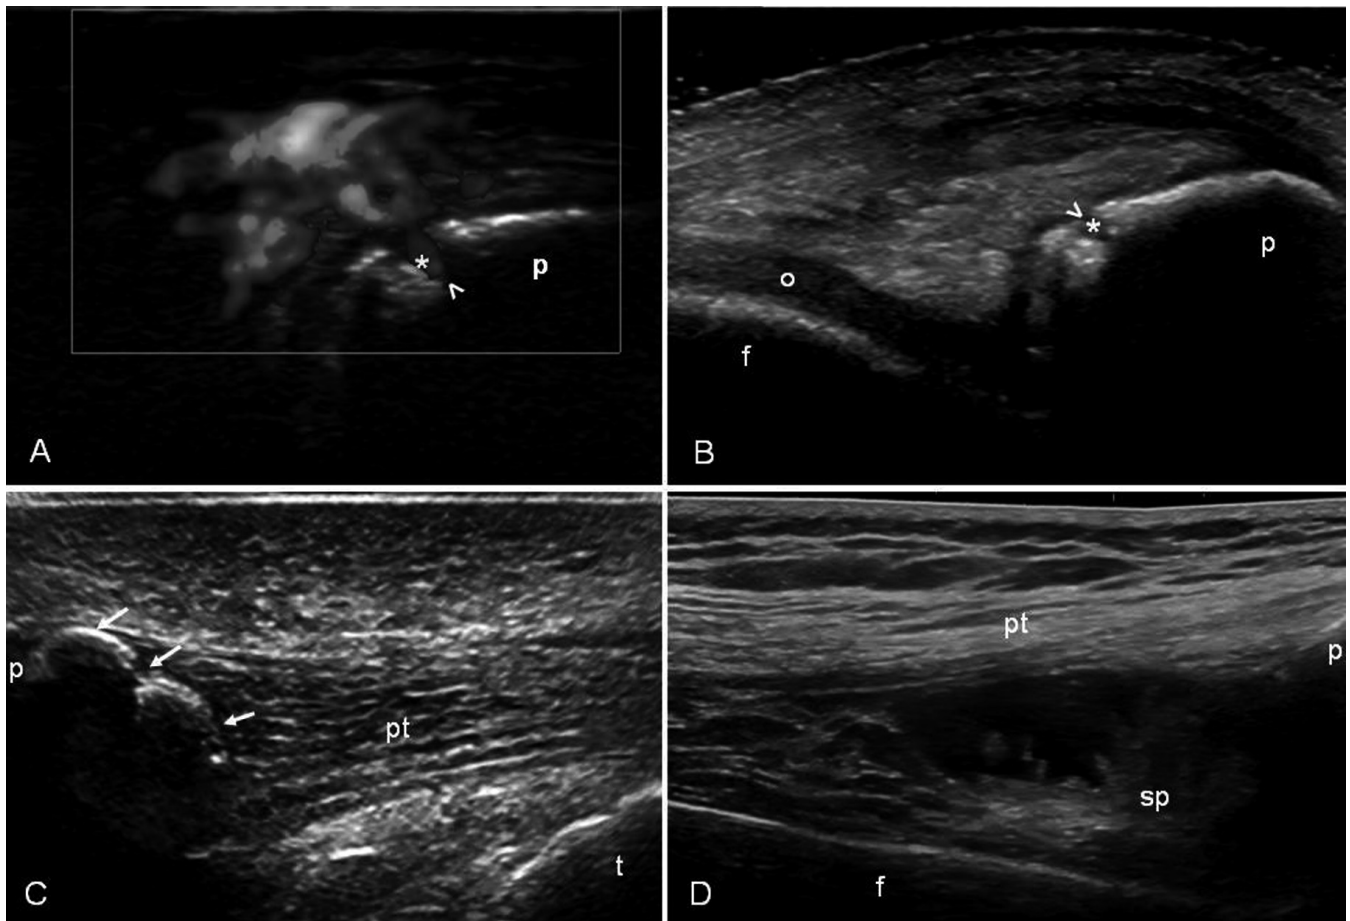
A. Dorsal transverse scan of the upper pole of the patella. Power Doppler technique showing the presence of signal in the quadriceps tendon and into an erosion. p: patella; arrowhead: patellar cortical bone erosion.
